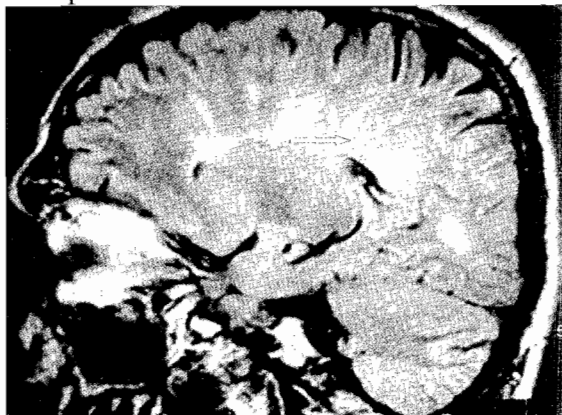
Fast FLAIR images obtained in a 40-year-old woman shows subcallosal striation (arrow).
